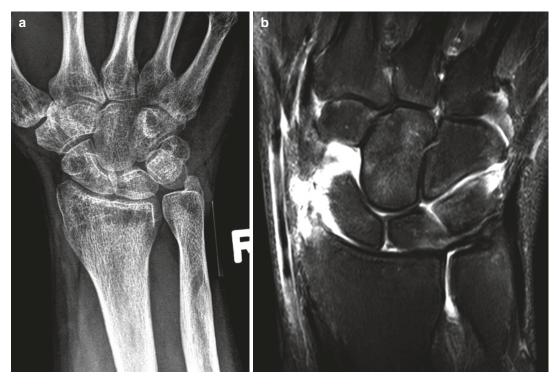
CRPS in a 25-year-old male with post-right elbow fracture who developed swelling and hyperalgesia of the right wrist. (a) PA radiograph demonstrates patchy
